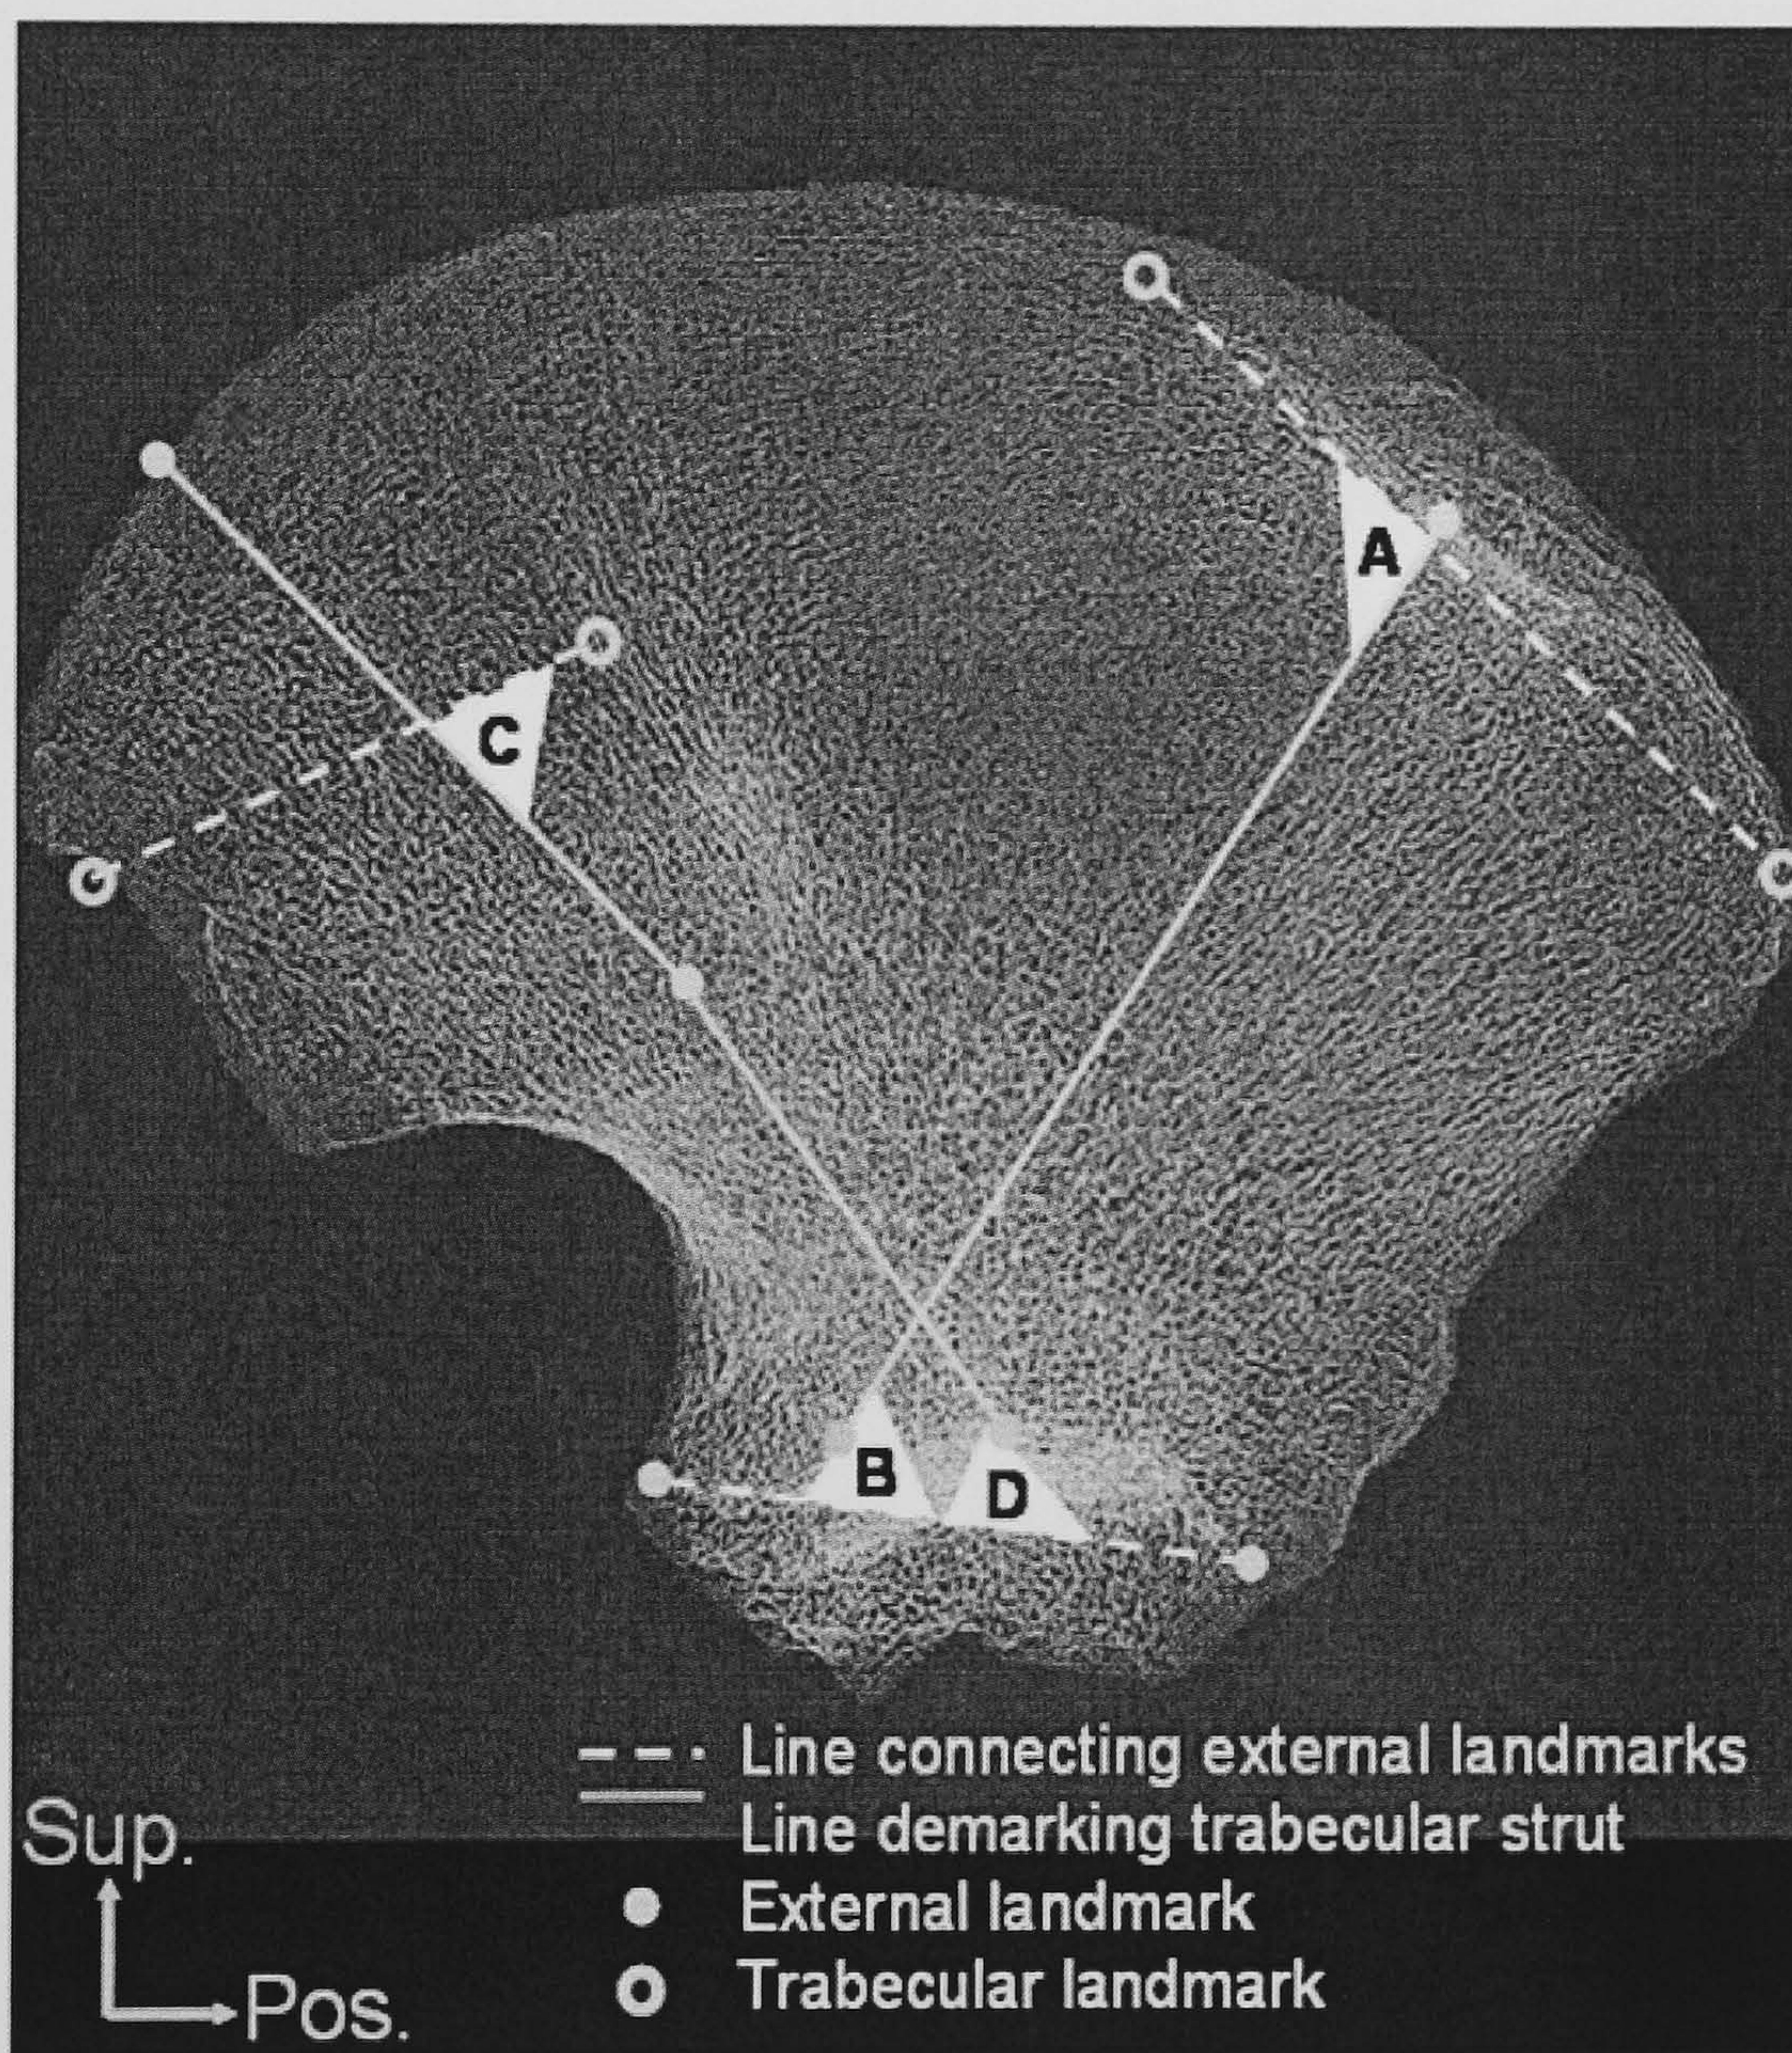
Measured angles of main trabecular bundle orientation. Open circles denote external landmarks and closed circles denote internal landmarks. Strut orientation was characterised in relation to external morphology by calculating angles where lines demarcating trabecular struts intersected lines connecting external landmarks. Triangles denote four measured angles of trabecular orientation, A, B, C and D. Radiograph from Macchiarelli *et al.* (2001).
